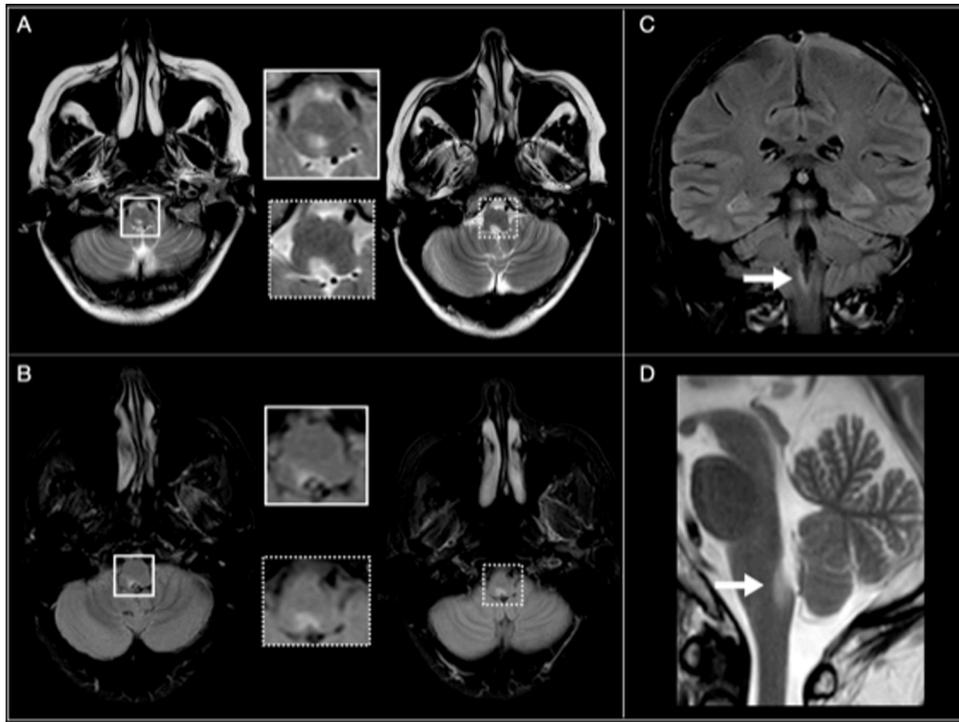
Lesion in the area postrema in a MOGAD patient. Brain images from patient number 8. A-Axial T2-weighted MRI and B-Axial T2-FLAIR, squares magnify hyperintense lesion in dorsal medulla. C-coronal T2-FLAIR, and D Sagittal T2-weighted Arrows point to the same lesion.
